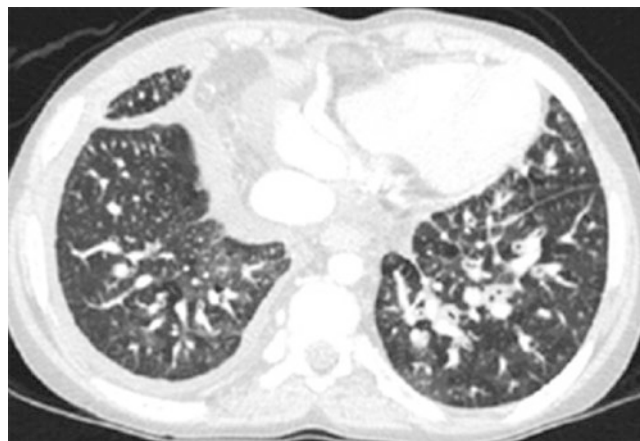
Lymphangiectasis: Axial lung window CT image reveals diffuse bronchial wall thickening, intralobular septal thickening, mosaic opacifications, and bilateral pleural effusions in this child with lymphangiectasis. There is incidental fatty infiltration of the mediastinum
